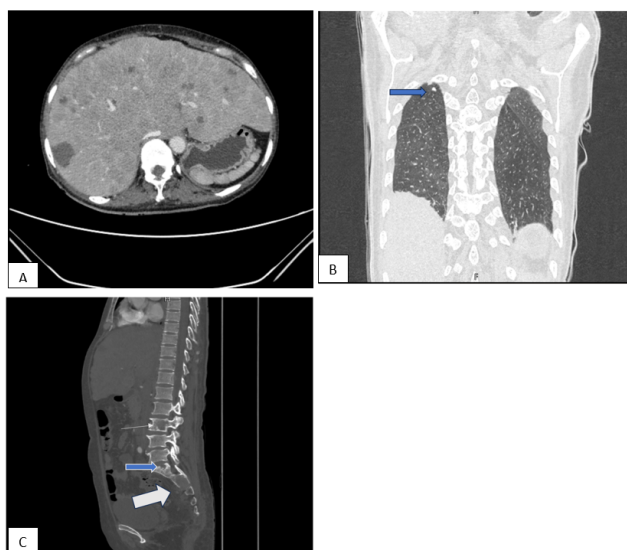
A): Response assessment CT shows 20% decrease in the largest diameter of liver lesion; B): CECT Chest shows two pleural-based lesions detected in the right apical lobe of the right lung (largest diameter 9 x 4 mm); C): Sagittal section shows multiple lytic lesions in the lumbar and sacral vertebrae
